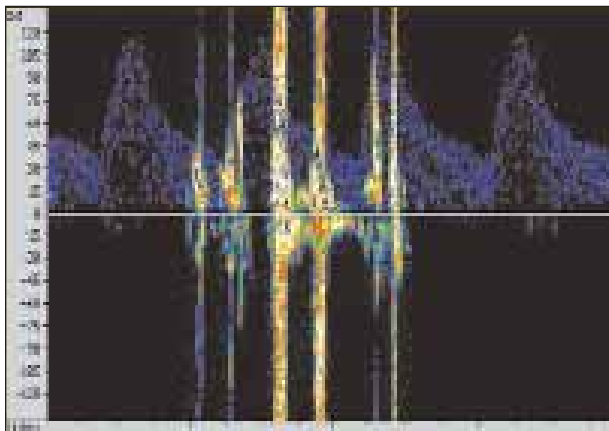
Transcranial Doppler image of showers of particles during lesion crossing.
